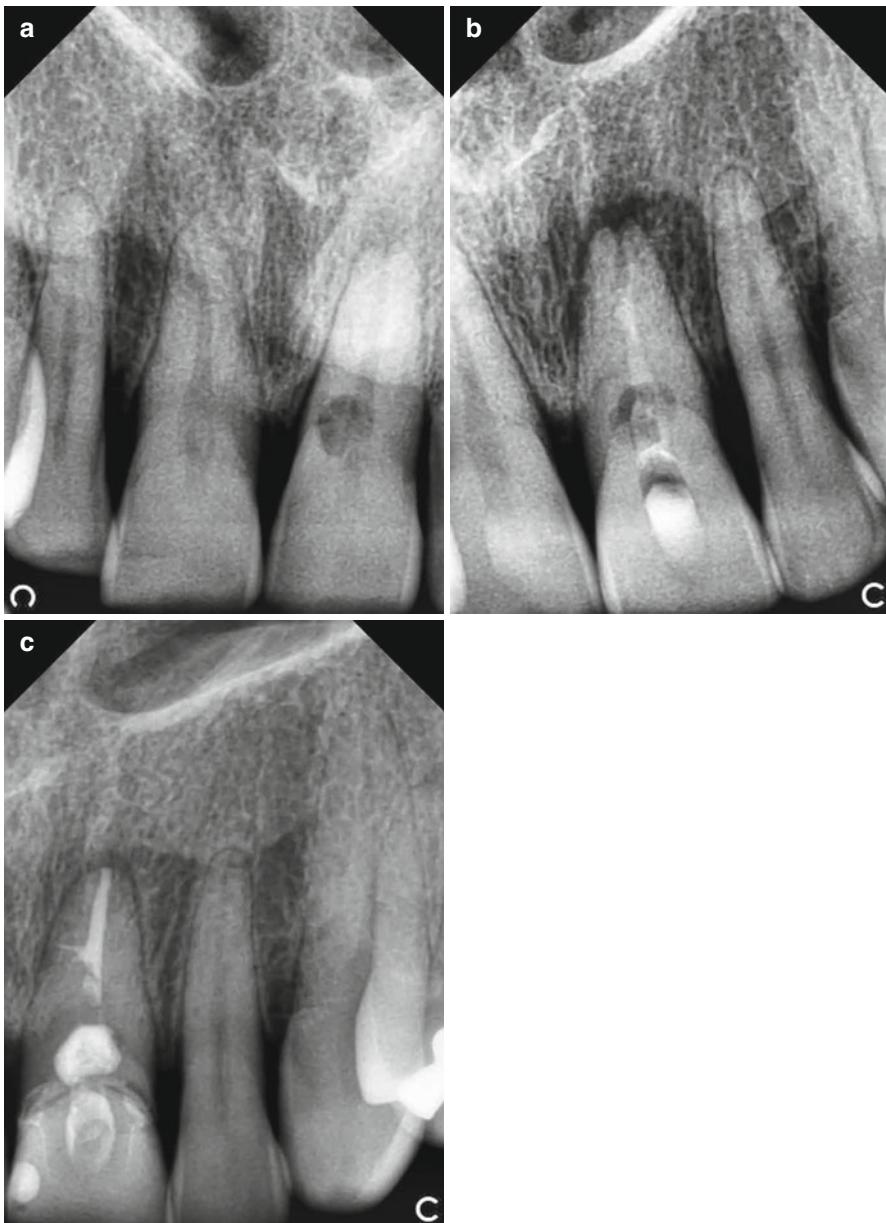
(a) A patient presented to the clinic complaining of an unusual “bump on her gum”. Intraoral examination revealed localized swelling on the labial mucosa, buccal of left maxillary central incisor. Probing around the tooth was within normal limits and the patient was asymptomatic. Percussion was inconclusive on all anterior teeth. The patient could recall a history of dental trauma a year prior to the examination. This periapical radiograph of the left maxillary central incisor shows a periapical radiolucency with what seems to be a communicating internal-external inflammatory resorption. The tooth tested non-vital to pulpal testing. (b) Endodontic treatment was initiated and an attempt to induce calcification by using calcium hydroxide alone was made. (c) Root canal therapy was completed and adjunct surgical procedure was performed to apply ProRoot MTA (Dentsply Tulsa Dental Specialties) on the buccal aspect of the root, where the resorption communicated with the periodontal ligament space. A fiber post was bonded into the root canal and a provisional crown was fabricated
